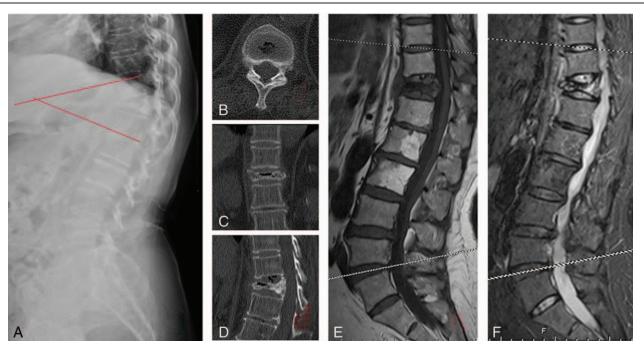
A is preoperative lateral X-ray; B, C, and D are preoperative CT; E and F are preoperative MRI. CT = computed tomography, MRI = magnetic resonance imaging.
